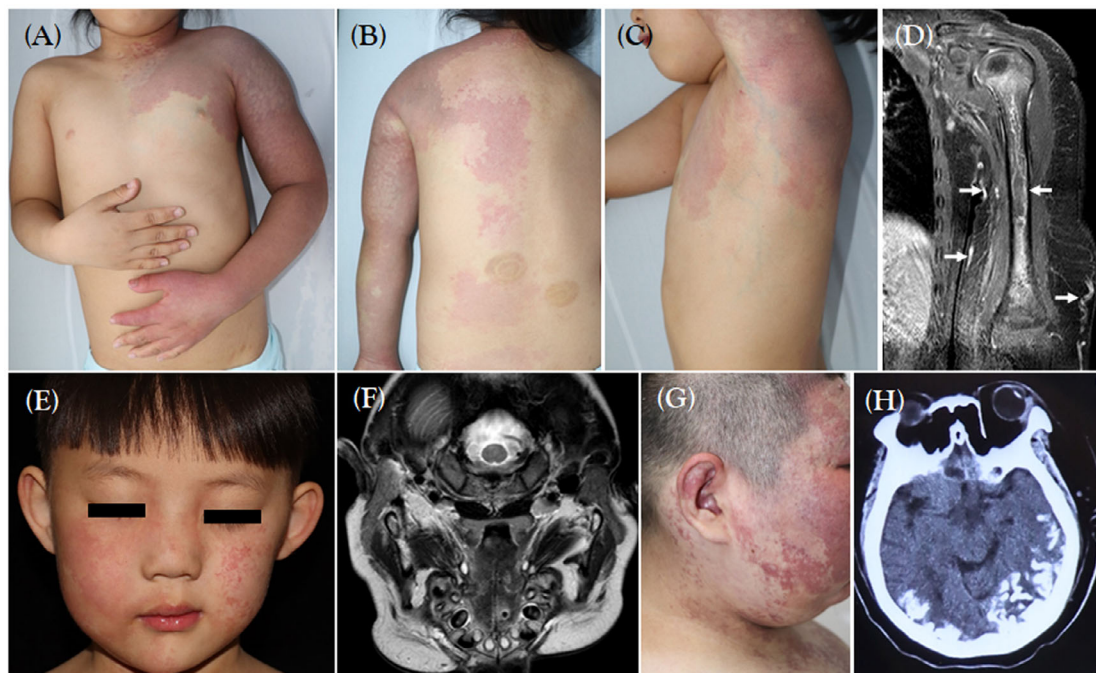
Systemic involvement of PPV. (A–D) Patient 1 with KTS, the affected limb was thickened compared with the opposite side. MRI indicated that the fat layer was significantly thickened, and there were multiple network high-signal shadows (white arrow) in the fat layer, muscle, and bone. (E, F) Patient 9 with DCMO, MRI indicated that the fat layer was locally thickened compared with the opposite side, and the empty small blood vessel shadow was increased. (G, H) Patient 6 with SWS, cranial MRI indicated tortuosity strip calcification in bilateral temporal and occipital lobes, distributed along gyri. DCMO, diffuse capillary malformation with overgrowth; KTS, Klippel–Trénaunay syndrome; MRI, magnet resonance imaging; PPV, phakomatosis pigmentovascularis; SWS, Sturge–Weber syndrome.
